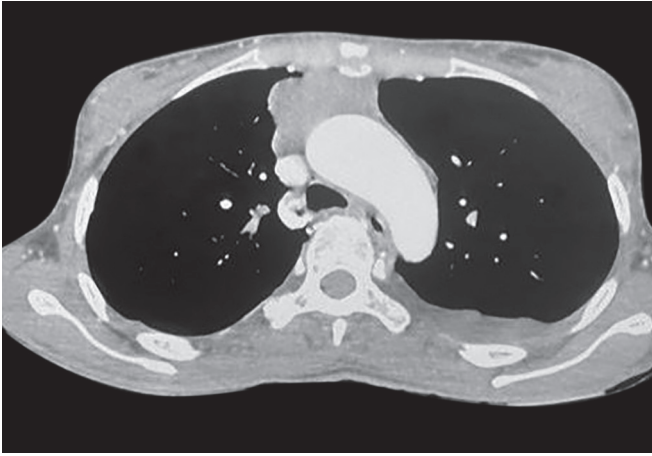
Computed tomography scan showing lobular thymic enlargement
